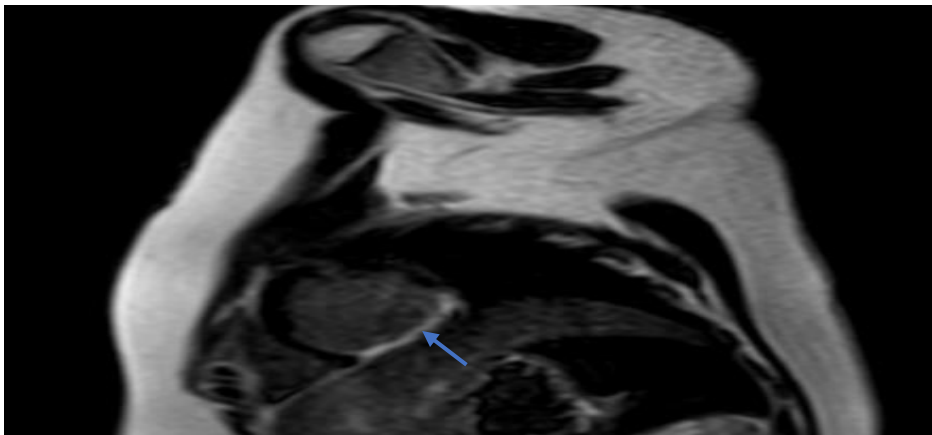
Cardiac MRI showing LGE enhancement in inferior wall transmurally as indicated by arrow suggestive of scar due to infarction. LGE- Late Gadolinium Enhancement.
